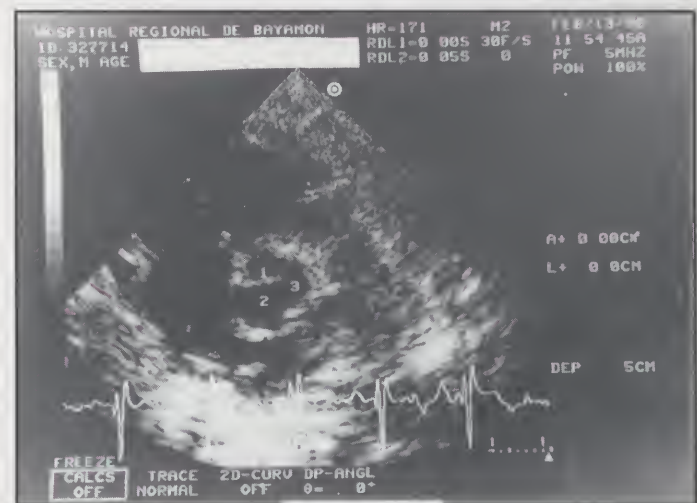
Two - D parasternal short axis view showing dilated left coronary cusps (2).
